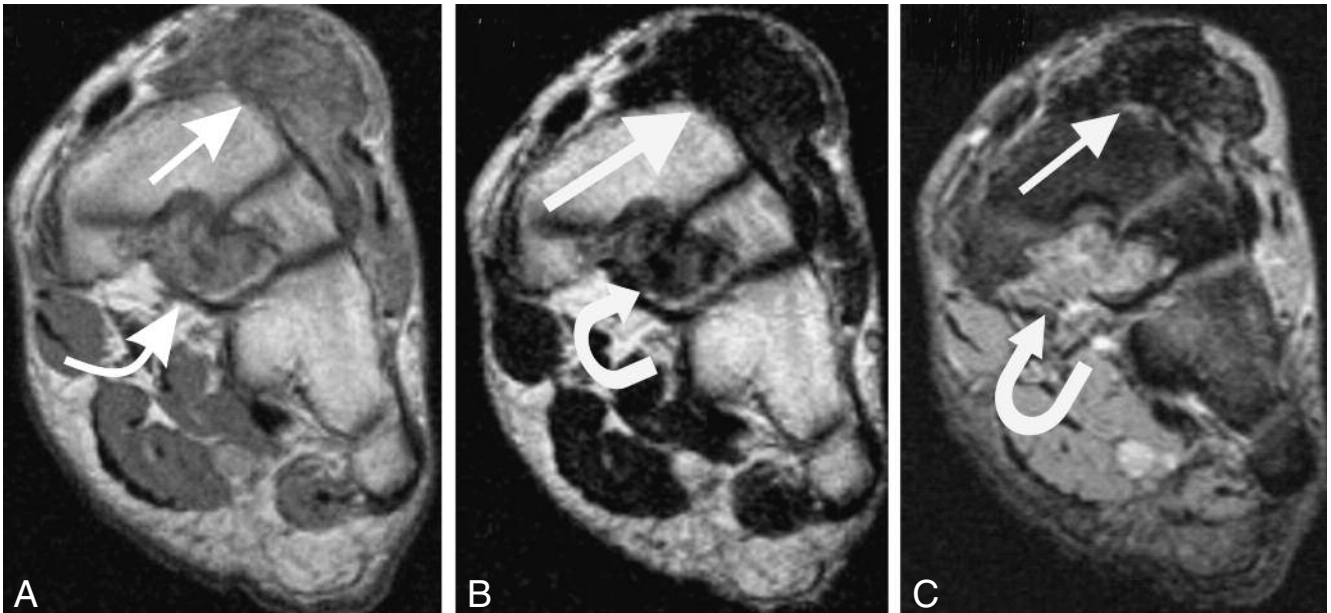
A. PD and (B) T2 SE as well as (C) T2 GE coronal images demonstrate intermediate and hypointense signal intensity respectively for proton density and T2-weighted images, whereas T2 GE sequence shows hypointense signal intensity for the superficial aspect of the lesion (straight arrow) with small areas of very low signal intensity indicating the presence of hemosiderin. A heterogeneously increased signal intensity at the deep aspect of the soft tissue mass could suggest the presence of synovitis (curved arrow).
